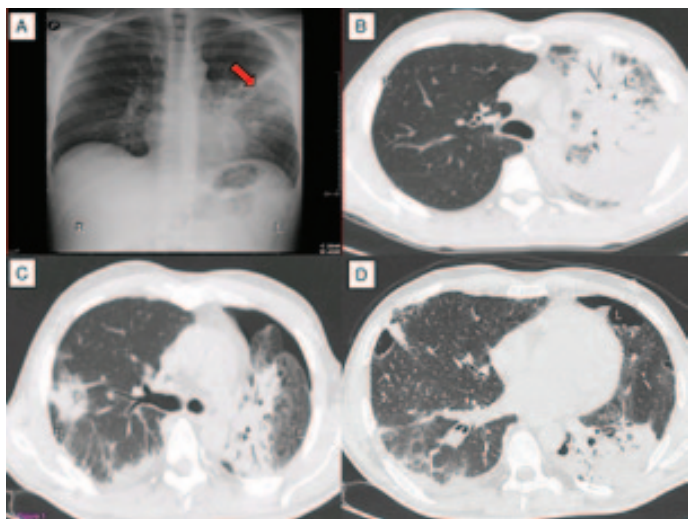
Chest X-ray and computed tomography (CT) images. A) A chest X-ray taken on admission: extensive pulmonary consolidation can be seen in the upper left lobe (arrow). There was an absence of pleural effusion and no cardiomegaly. B) A chest CT scan taken on the ninth day: consolidation areas can be seen on the whole superior left lobe, mixed with ground-glass areas and air bronchogram. There was an absence of pleural effusion. C, D) A CT scan taken on the 21st day: on the left there is parenchymal consolidation with air bronchogram and pneumothorax, and several areas of parenchymal consolidation on the right superior lobe. There was an absence of pleural effusion.
